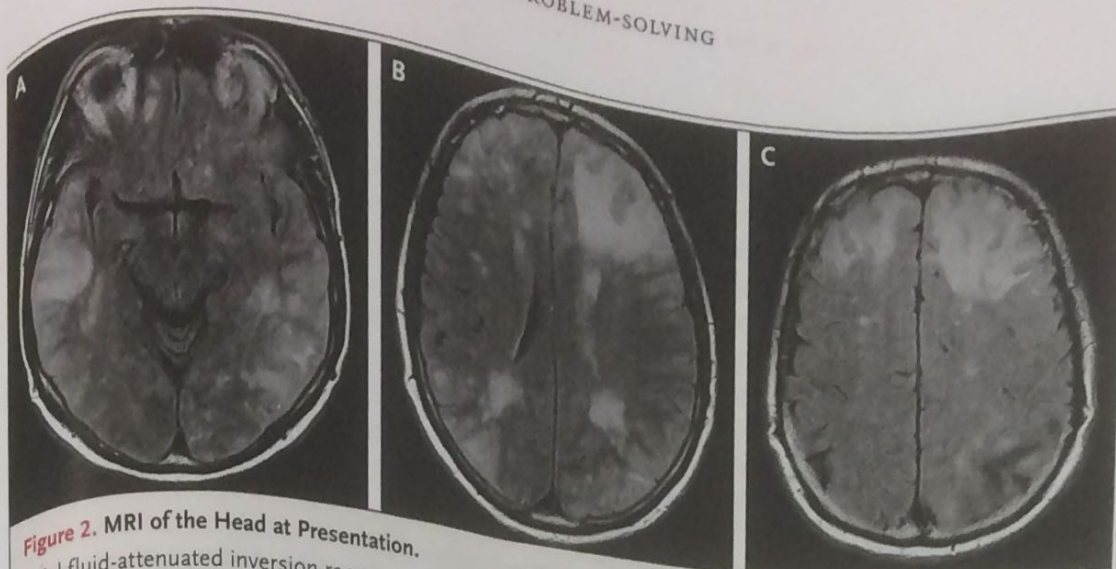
MRI of the Head at Presentation.
